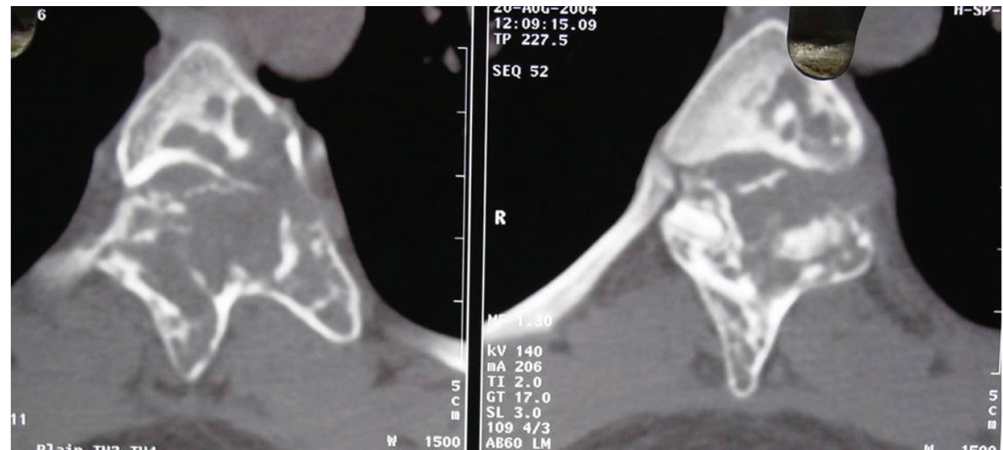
Case 1 imaging photographs (CT pictures)
